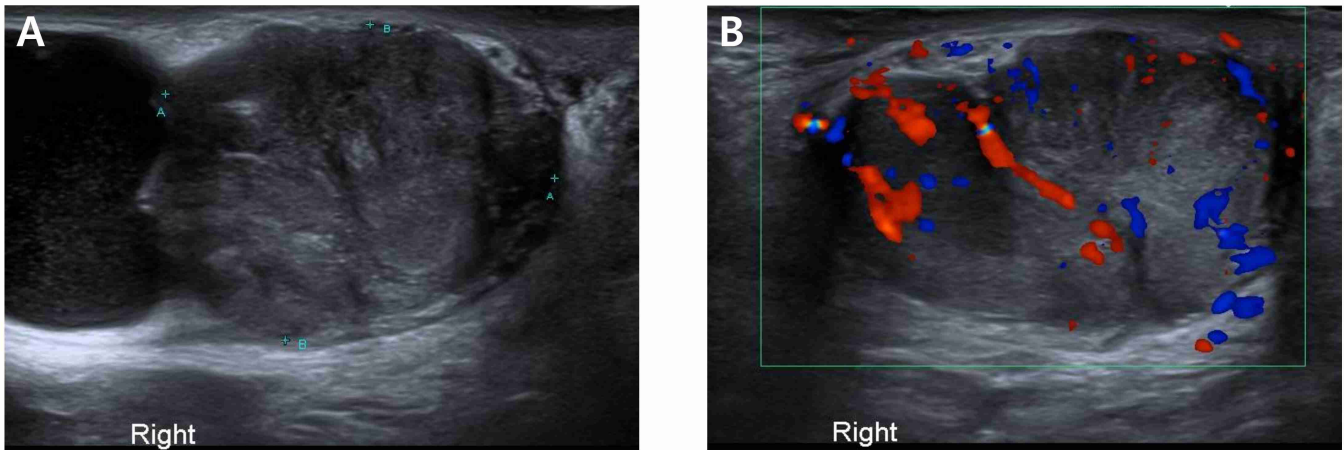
Ultrasound scan images. (A) Ultrasound scanning for right testicular mass. (B) Ultrasound scanning with color doppler mode for right testicular mass.
